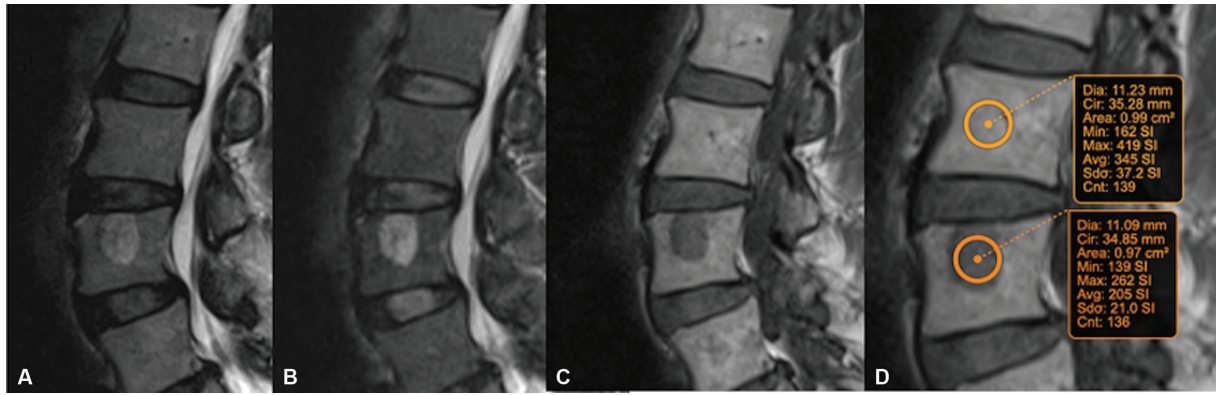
Sagittal T2-weighted (A), short tau inversion recovery (B), and T1-weighted (C, D) images from the normal cohort with an atypical hemangioma in L3 vertebral body. The lesion is bright on the fluid-sensitive sequences (A, B) and mildly hypointense on T1-weighted imaging (C). (D) Calculation of T1 ratio of marrow of the atypical hemangioma/ normal marrow. The ratio is $205/354 = 0.6$
